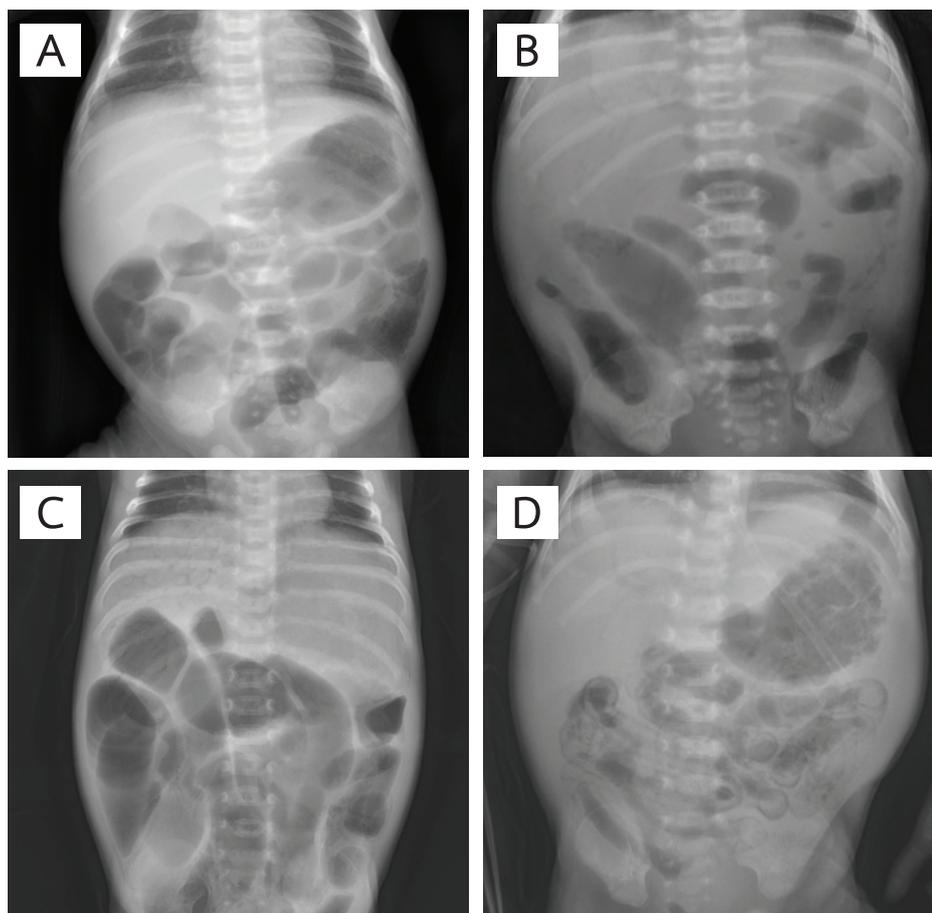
(A) Supine abdominal X-ray showing nonspecific diffuse bowel dilatation with foci of pneumatosis (left lower quadrant) upon presentation on DOL 9. (B) Diffuse dilatation of bowels with foci of portal vein gas (right upper quadrant) at 6 h after presentation on DOL 9. (C, D) Recurrent pneumatosis and portal vein gas on DOL 27
